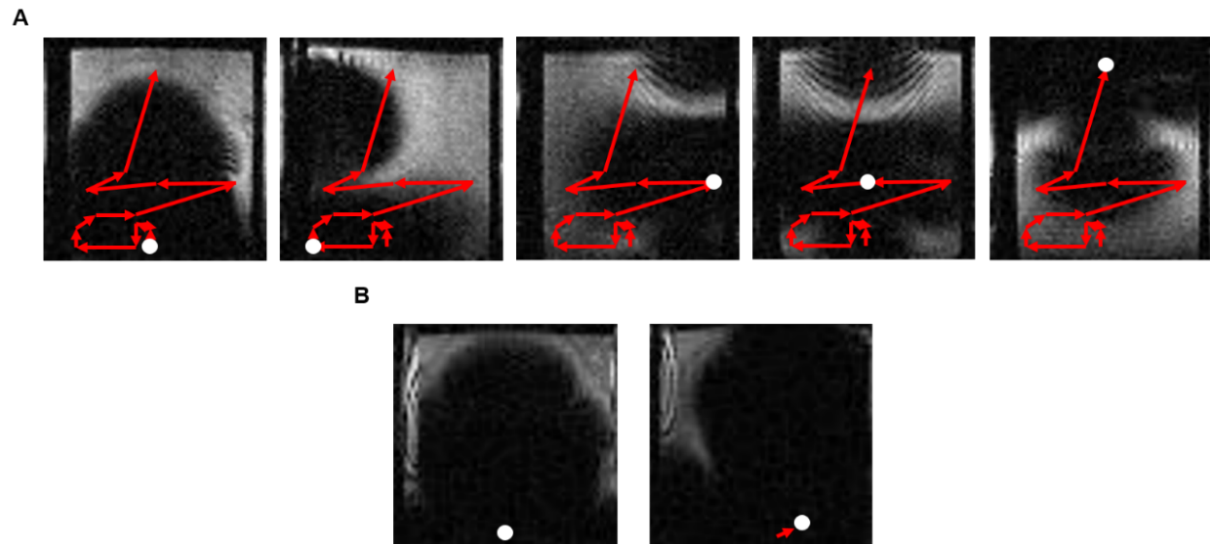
Distance moved can be controlled with gradient strength and seed size. A) MRI images showing the characteristic susceptibility artefact produced by the seed at different points as it is rastered through agar. Red arrows indicate each individual movement. White circle indicates position of seed. B. Graph showing the distance moved for a 0.5mm and 1mm seed for a given gradient strength. (Error bars = SD.  $N > 3$  for all conditions) C. Theoretical magnetic force applied to seeds of different sizes at different gradient strengths.
